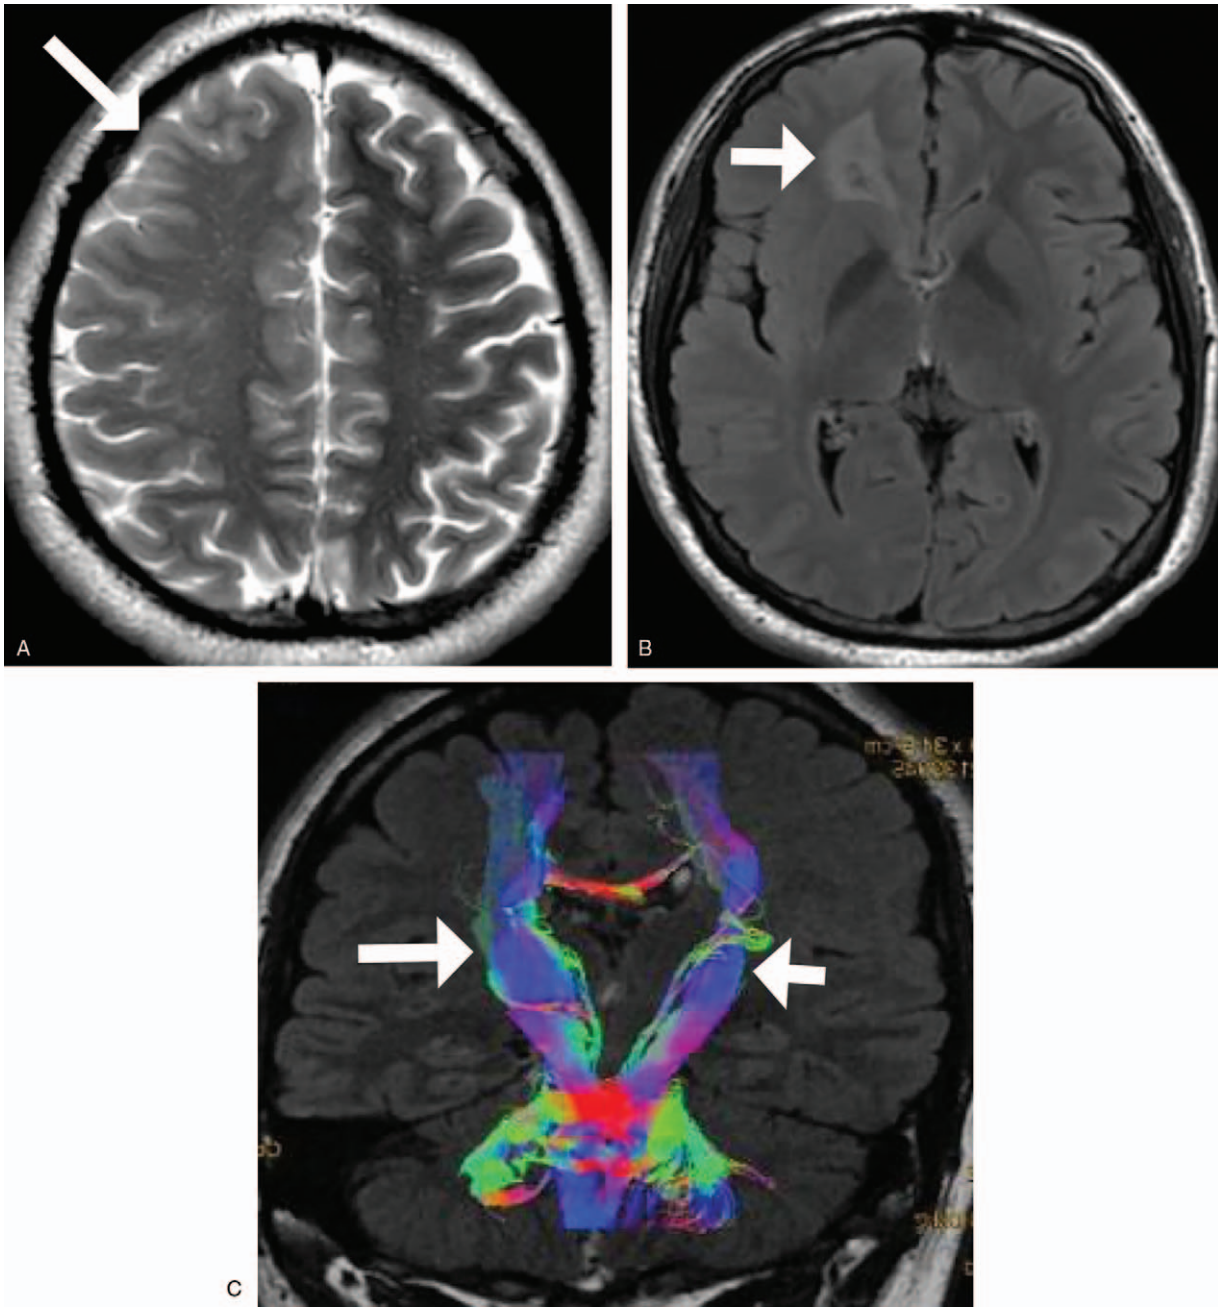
27-Year-old man with hypomelanosis of Ito. Axial T2-weighted image (A) shows hemimegalencephaly of the right cerebral hemisphere (white arrow). Axial T2-FLAIR image (B) shows white matter signal abnormalities in the right frontal lobe (white arrow). Coronal T2-FLAIR with superimposed tractography (C) shows asymmetry of the corticospinal tracts, the right (long white arrow) wider than the left (short white arrow).
